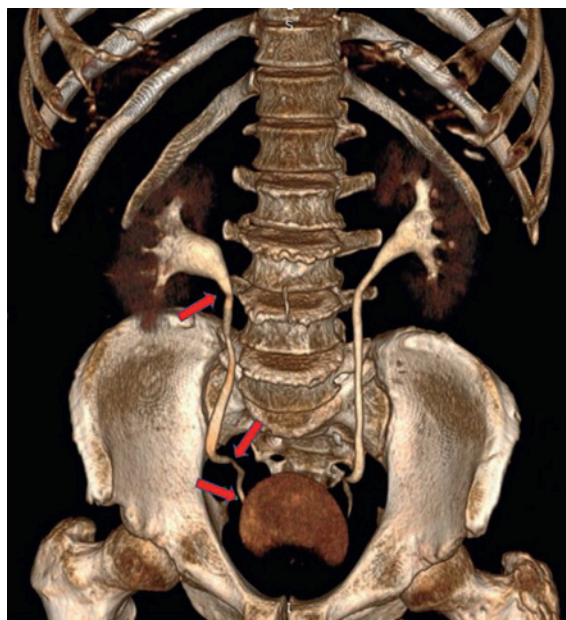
Three-dimensional model created by computed tomography scan of the upper urinary tract (red arrows indicate the levels of measurement of the diameter in areas of physiological narrowings of the ureter)
